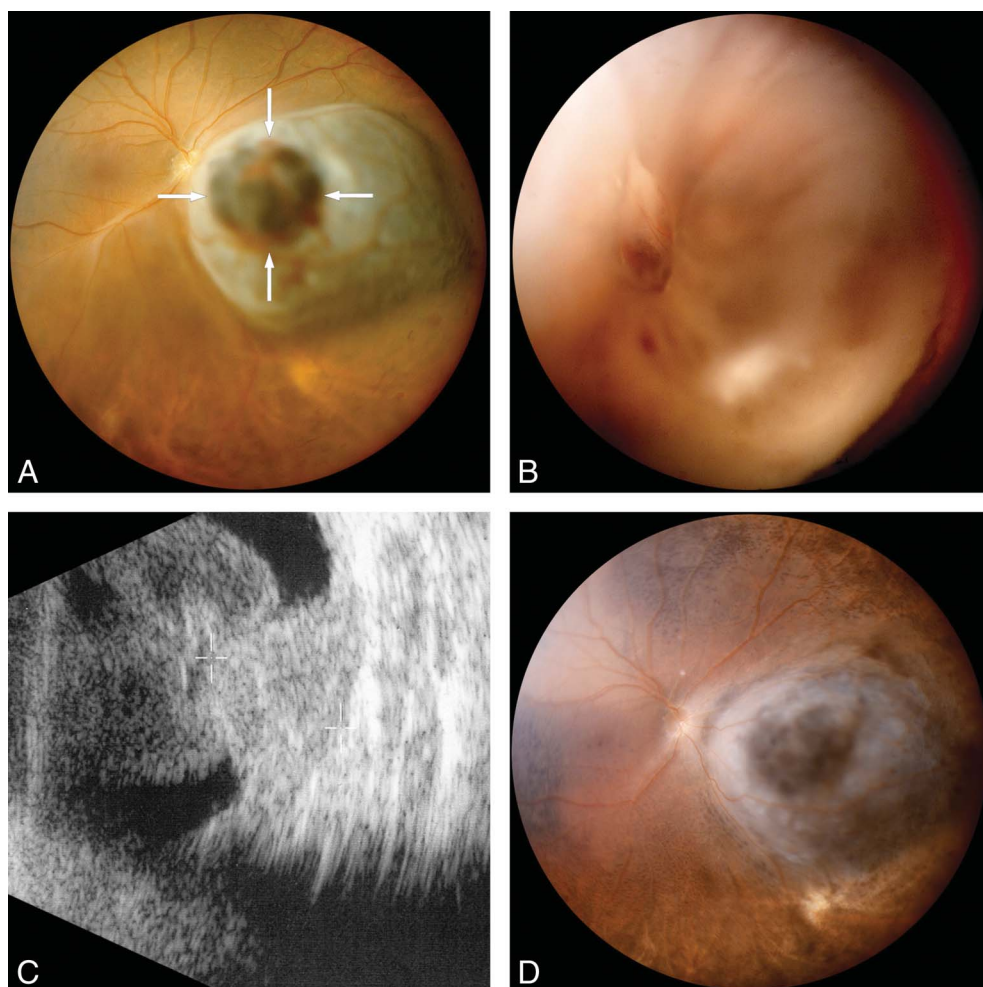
Panoramic fundus pictures (Panoret camera) of a VH after proton therapy of a Knapp-Ronne type melanoma. A. A 55-year-old man had a parapapillary, nasal choroidal melanoma, presenting a hemorrhage at its surface and an invasion of the retina (white arrows). Despite the presence of a secondary serous RD, his best-corrected visual acuity (BCVA) was 20/25. He was treated with proton therapy. B. Six months later, his BCVA had dropped to light perception, related to a VH. C. On B-scan ultrasonography, the VH was shown to originate from the apex of the tumor, which had regressed from an original thickness of 8.4 mm to 7.8 mm. A simple uneventful vitrectomy was performed. D. Five months later, the tumor scar remained perfectly visible, with a BCVA at 20/400, related to retinal atrophy.
